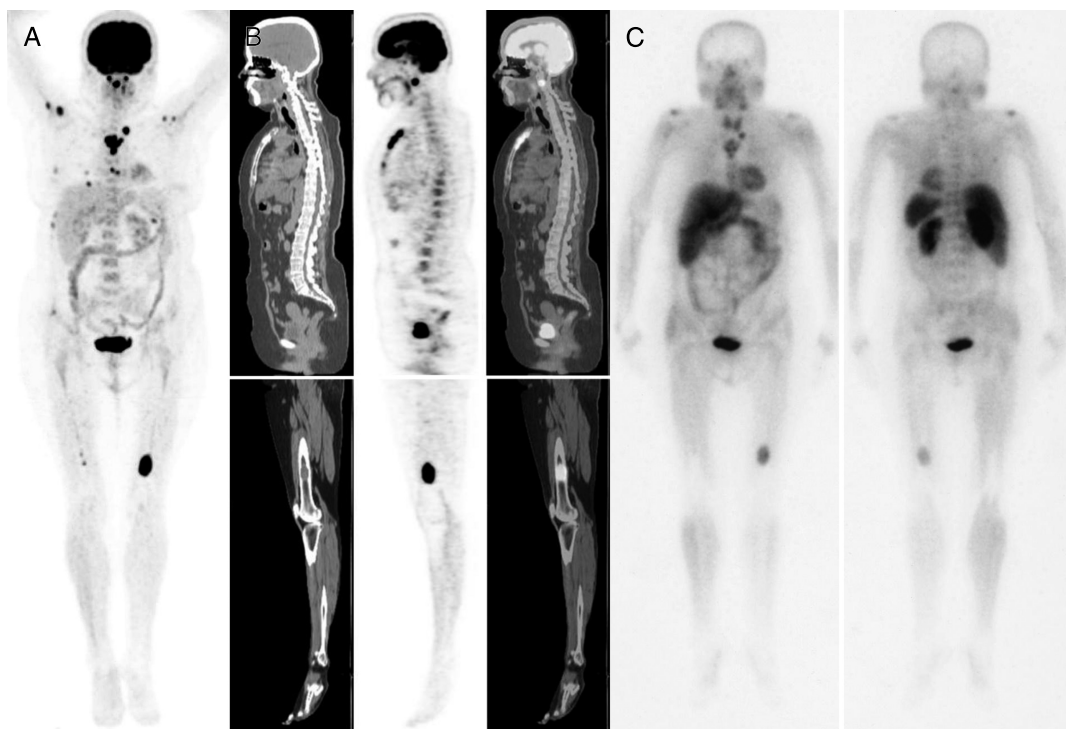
Whole-body ¹⁸F-FDG PET/CT and ^{99m}Tc-MIBI scans performed on the same MM patient showing diffuse tracer uptake and focal lesions in the axis, acromion processes, humeri, left clavicle, sternum, ribs, right ilium, and femuri. A, MIP view. B, Sagittal CT, PET, and fusion images of whole-body ¹⁸F-FDG PET/CT. C, Anterior and posterior whole-body ^{99m}Tc-MIBI.
